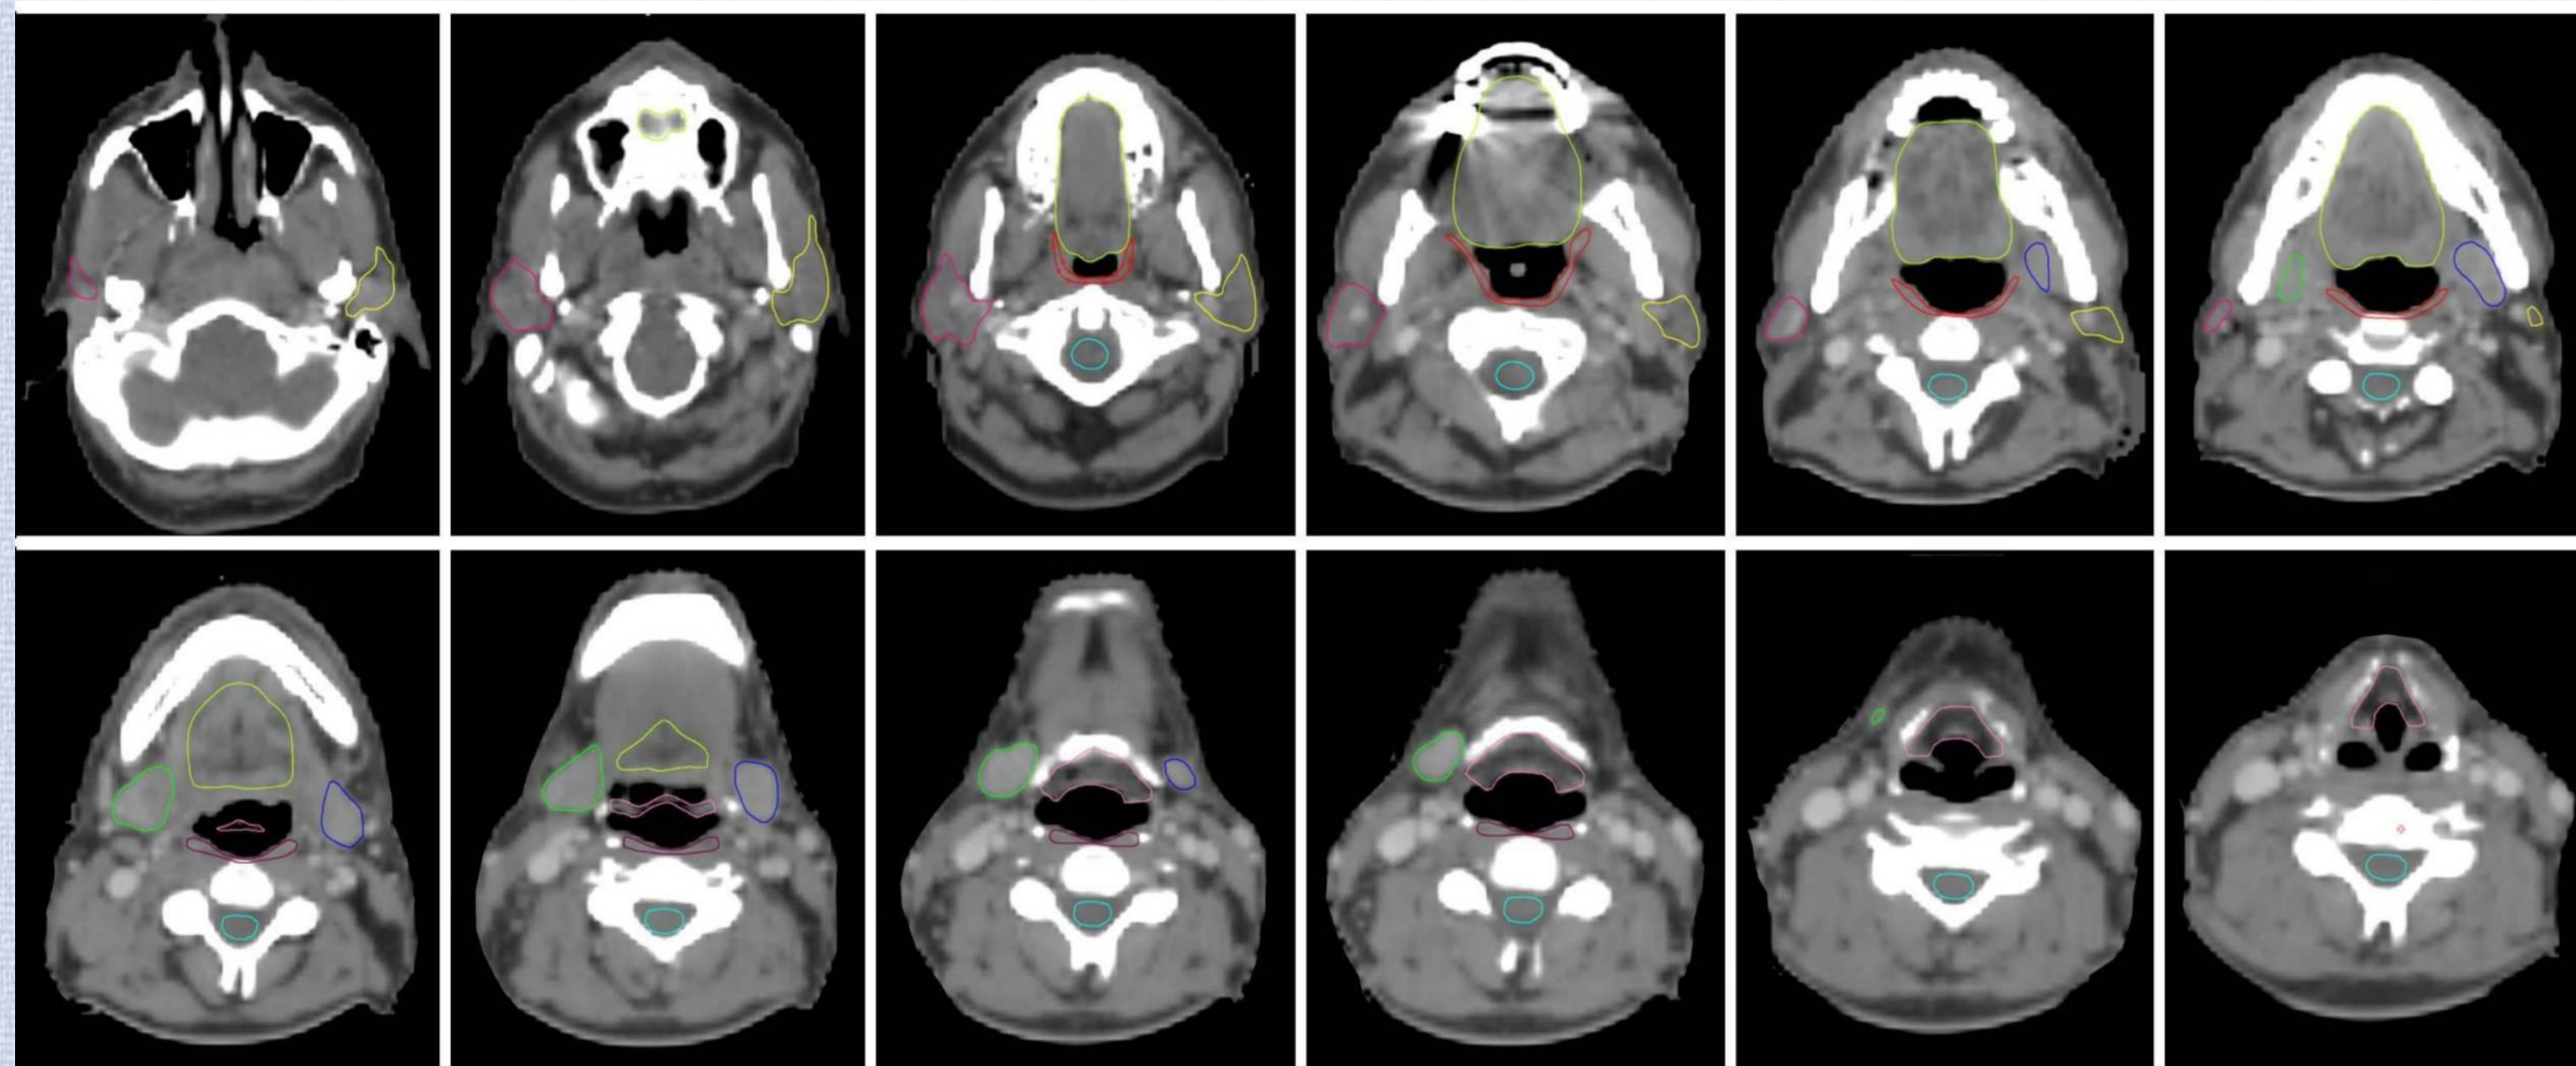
Example atlas of full 'swallowing OAR' structure set contoured on planning CT
